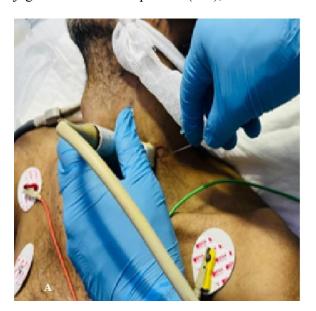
Transducer position and corresponding ultrasound image of the stellate ganglion block (SGB). A Performance of the SGB using transverse scanning with needle in-plane approach. B; Ultrasound images for the SGB. The internal jugular vein was compressed (IJV); CA carotid artery, VB C6 vertebral body.
